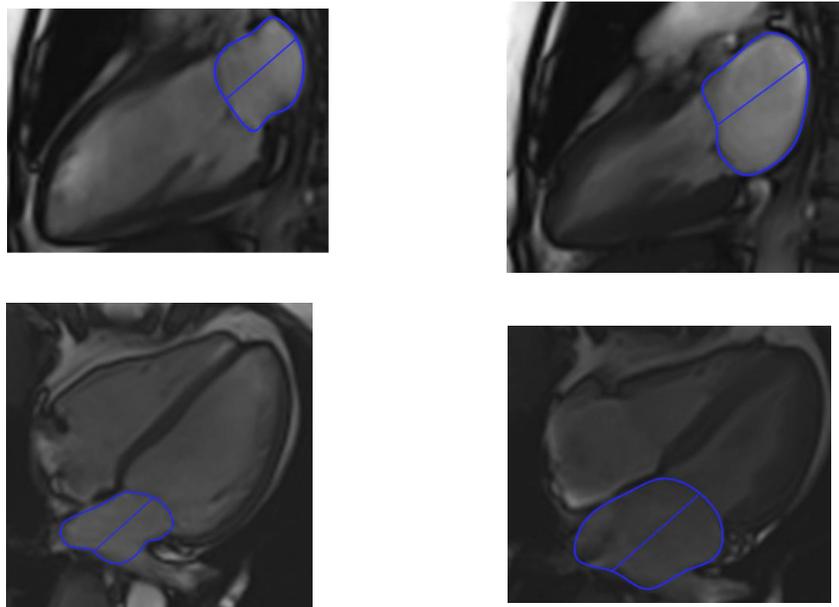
Measurement of left atrial minimal and maximal volumes. Cine-MRI slices were acquired in the two-chamber (upper row) and four chamber (lower row) long-axis orientation. Minimal (A and B) and maximal left atrial (C and D) volumes were calculated using the biplane area-length method. The atrial appendage and the pulmonary veins were excluded from the measurements.
